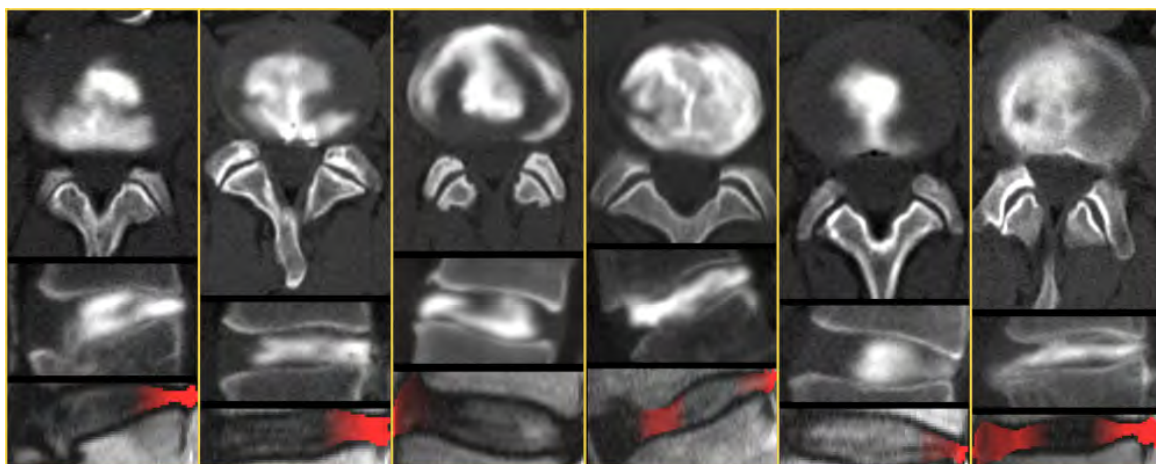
Representative examples of CT-discograms (top and middle) and the corresponding attention maps overlaid on a sagittal T2W MR image (bottom). The sagittal images display the posterior IVD on the right side. The figure displays instances where the attention maps correctly identify all outer annular fissures. The contrast media, injected into the NP (visible in white), spreads through annular fissures and their location is determined in the T2W MR image and highlighted in red.
